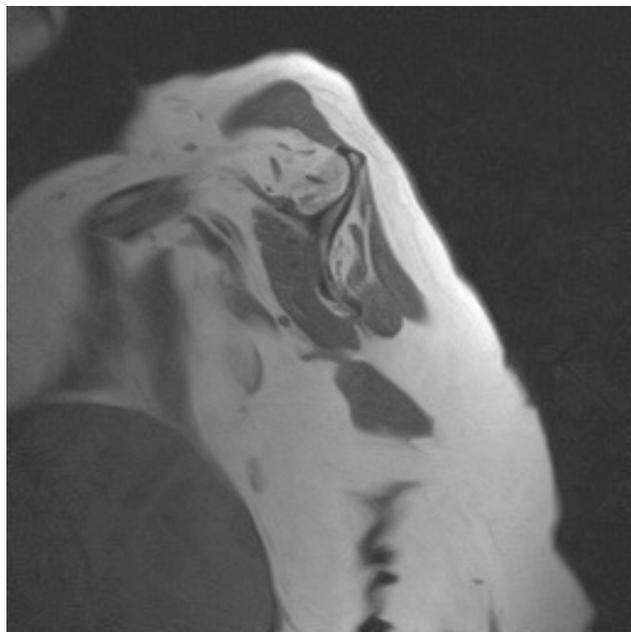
T1-weighted MRI showing grade 4 fatty infiltration in a patient with a large full-thickness supra- and infraspinatus tear.
